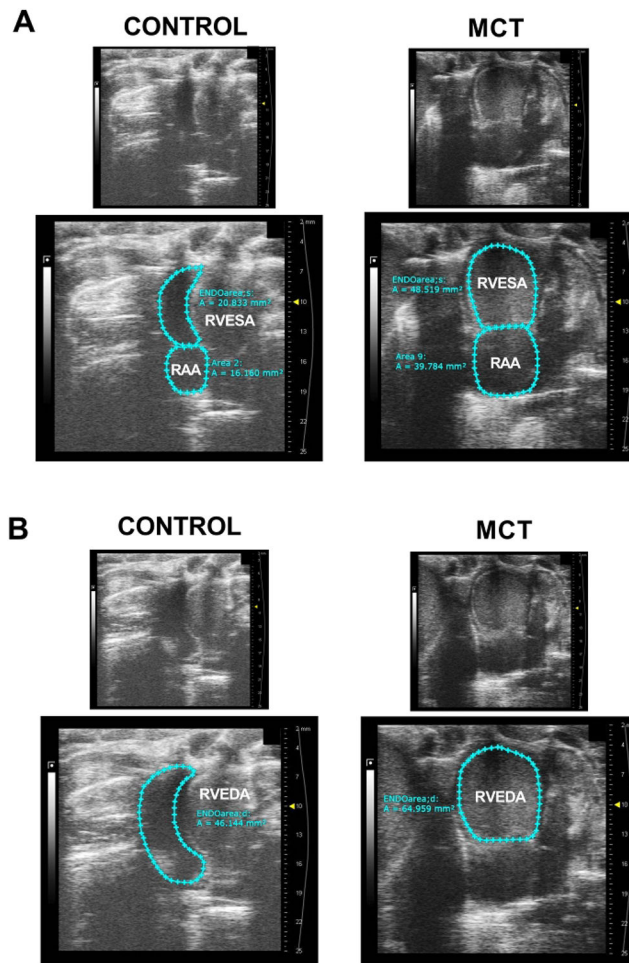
RV focused apical four-chamber view.
